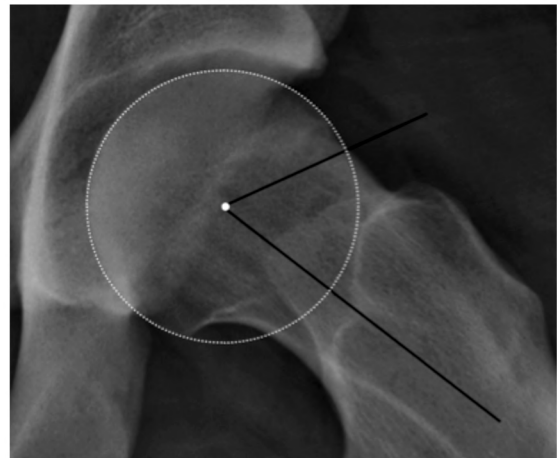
Plain radiography frog view of the left hip shows aspherical head in patient with cam type (FAI) with alpha angle=62 degree (normal <52 degree).
